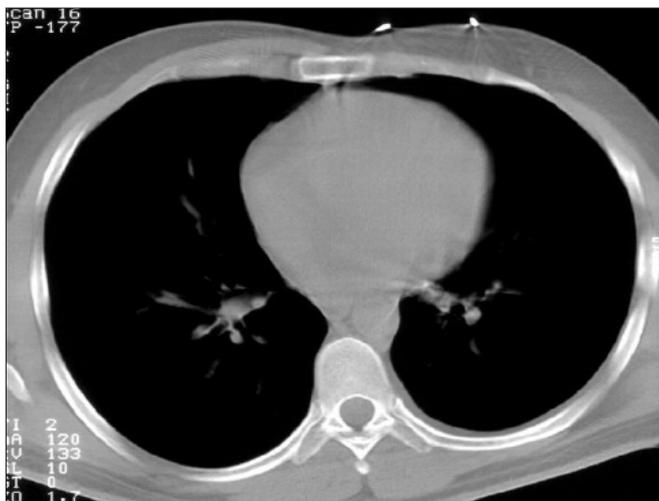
CT scan of the chest showing no gross abnormalities.
